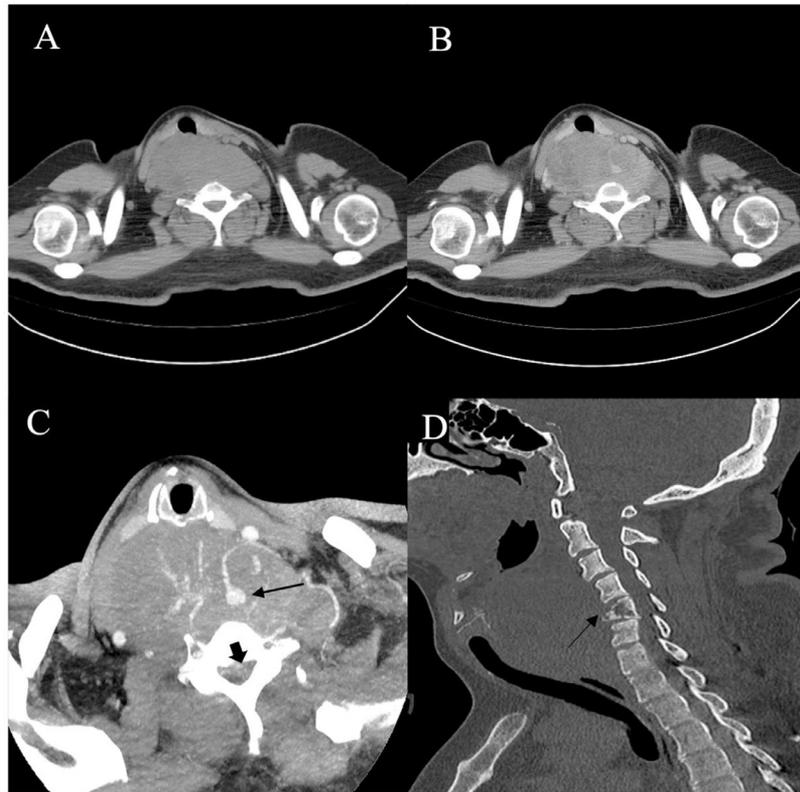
Axial (A), axial contrast-enhanced CT image (B), MIP of CTA (C), and Sagittal reconstruction of the cervical spine of a synovial sarcoma in the retropharyngeal space of a 32-year-old male patient. A bulky, lobulated, heterogeneously enhancing mass measuring 11.0 × 5.8 × 8.1 cm was observed. Mild enhancement was noted following intravenous administration. Prominent tumor vascular structures resembling “caput medusae” were visible centrally within the lesion (black arrow in C), and the tumor eroded into the spinal canal (thick arrow in C). The fifth vertebral body showed osteolytic destruction with compression fracture (black arrow in D, bone window).
